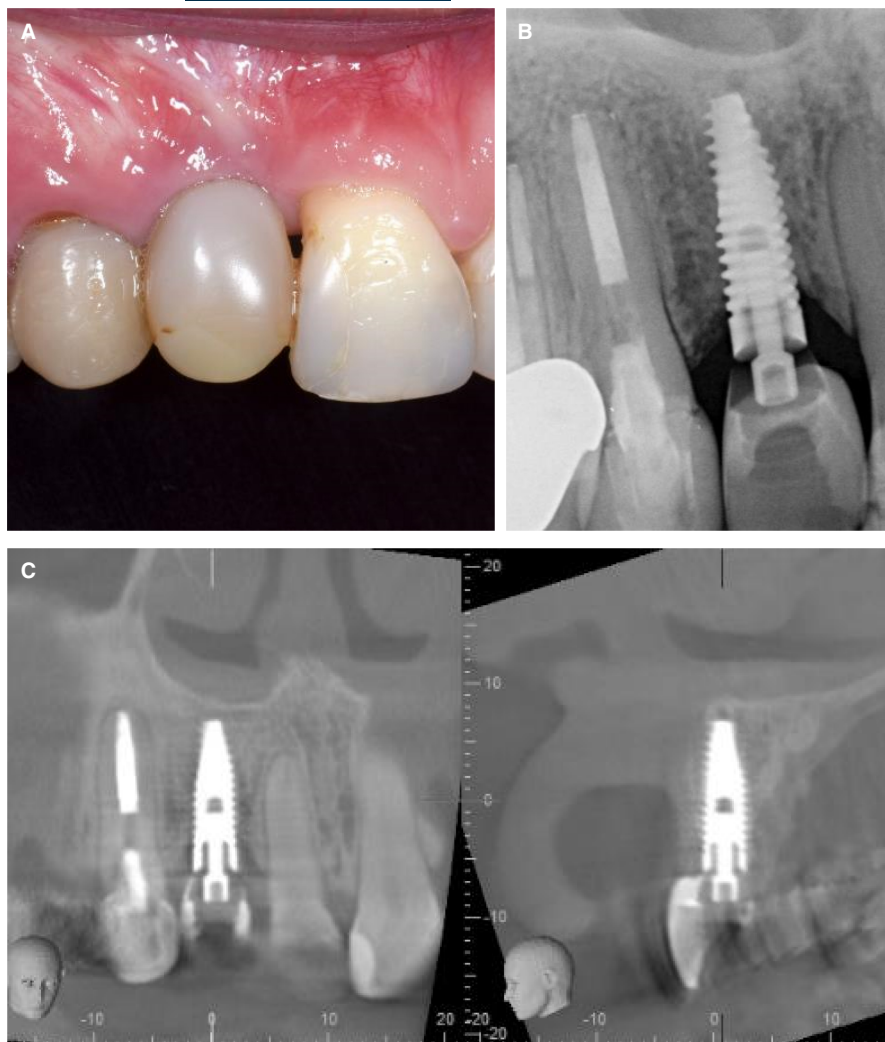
A, The implant in the maxillary right lateral incisor site has been restored with a provisional crown. The prosthesis has a ridge lap on the facial aspect. B, A periapical radiograph of the implant suggests that the implant has been placed with the shoulder positioned too far coronally. C, CBCT analysis confirmed that the shoulder of the implant has not been placed deeply enough. The implant is also in a palatal malposition. The consequence is that the prosthesis requires a ridge lap on the facial aspect. CBCT, cone beam computed tomography
